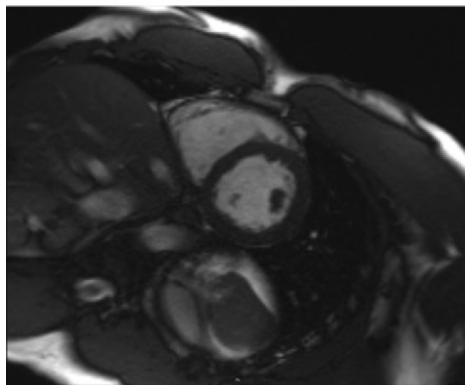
Parallel imaging. (a–d) SSFP MR images at 1.5 T show progressive loss of signal intensity with higher acceleration factors. Acceleration factors are 0 in a, 1 in b, 2 in c, and 3 in d. (e–h) SSFP MR images at 3 T show no appreciable signal intensity change with higher acceleration factors (1 in e, 2 in f, 3 in g, and 4 in h) because of higher SNR reserve and less impact of *g*-factors.
